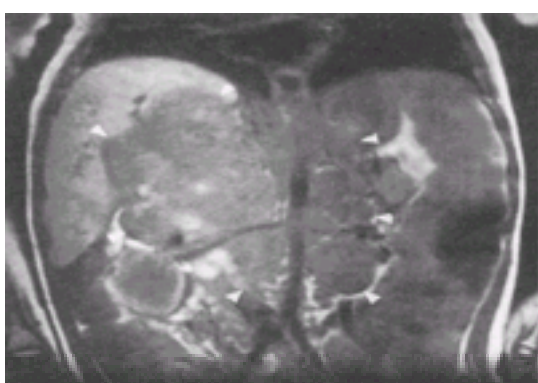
MRI scan of a 30-month-old child who presented with a large right adrenal neuroblastoma with extensive lymph node metastases (arrows) surrounding the aorta, vena cava, and the origin of the celiac axis and the superior mesenteric artery.
